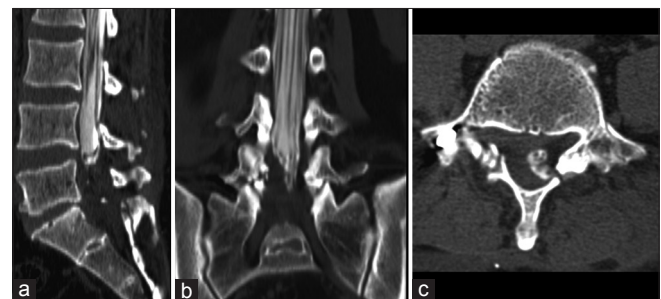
(a-c) Sagittal, coronal, and axial computed tomography myelogram images showing abrupt cutoff of thecal sac at L5 vertebral level, leftward displacement of thecal sac
